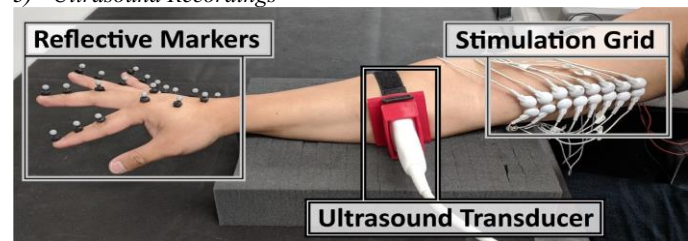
Experimental Setup. Reflective markers were placed on the hand to track finger motions and ultrasound was recorded along the forearm to image the changes in muscle tissue with contraction. A stimulation grid was placed along the medial side of the upper arm. Note: the hand was rotated for the purpose of the picture and does not represent the normal neutral position.
